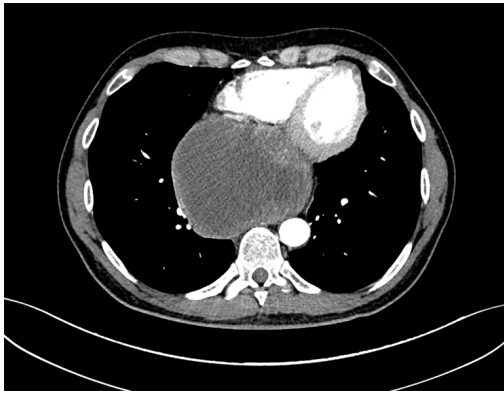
Contrast-enhanced computed tomography at diagnosis demonstrating the mass in the esophagus-gastric junction with extension in posterior mediastinum.
